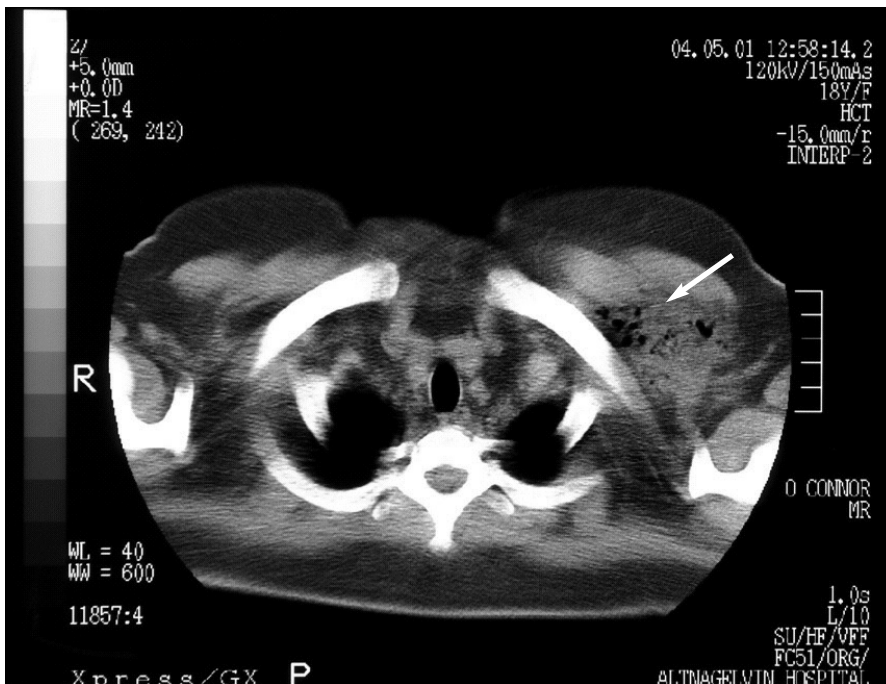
Computed tomography scan of the chest showing multiple gas bubbles (arrow) in the left pectoral muscle, consistent with abscess formation.
